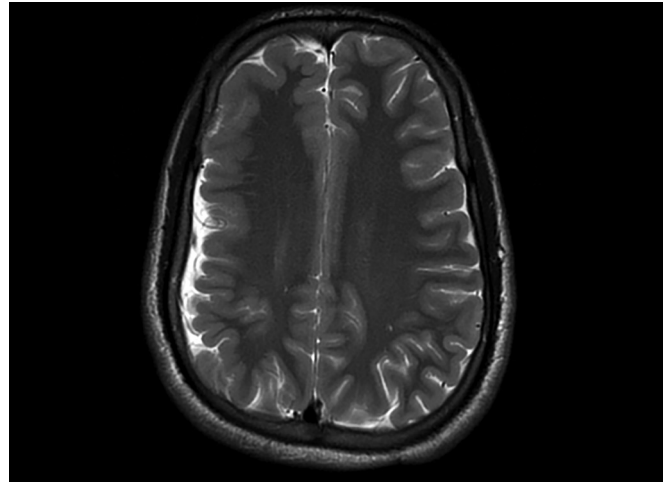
MRI brain showing polymicrogyria (multiple small and shallow gyri) in the right fronto-parietal cortex. There is dilatation of the overlying subarachnoid space
